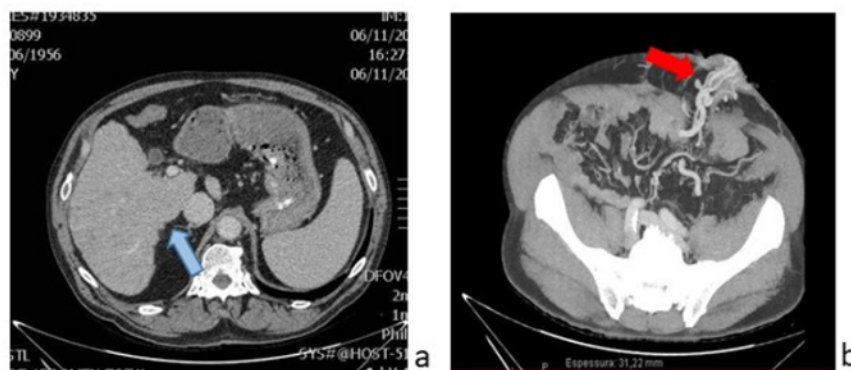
a: Computed tomography showing typical irregular and nodular hepatic contours compatible with cirrhosis; b: Calibrous variceal veins surrounding the stoma.
